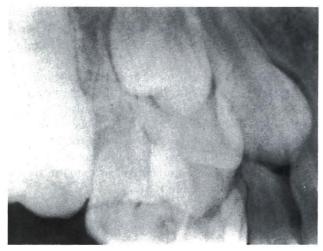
Maxillary right posterior periapical radiograph
